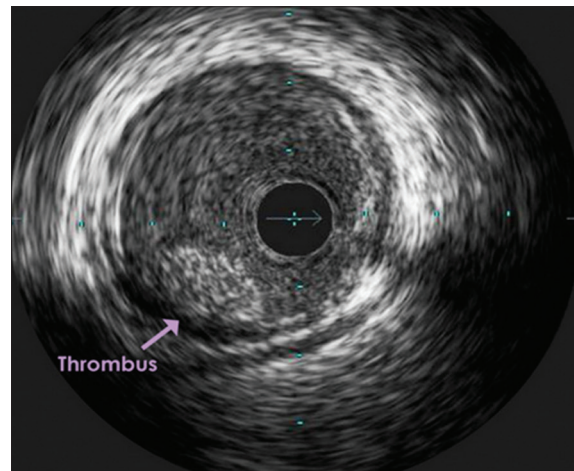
Intravascular ultrasound image of thrombus hypo dense (40 Hounsfield units s/o thrombus).
